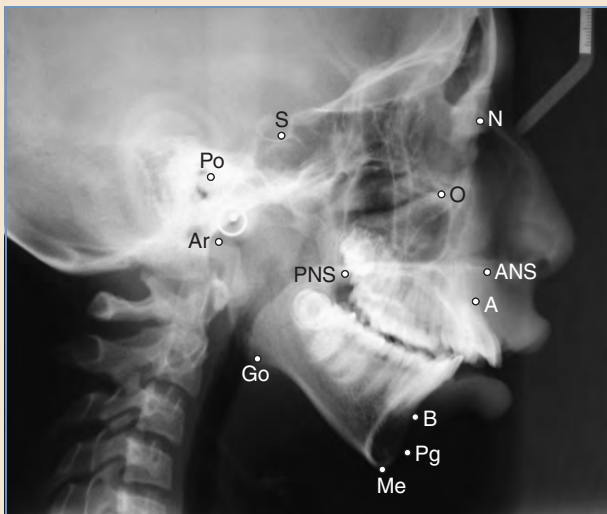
The facial skeleton is analyzed using cephalometric radiographs with anatomic landmarks. (*A*, A point; *ANS*, anterior nasal spine; *Ar*, articulare; *B*, B point; *Go*, gonion; *Me*, menton; *N*, nasion; *O*, orbitale; *Pg*, pogonion; *PNS*, posterior nasal spine; *Po*, porion; *S*, Sella.)
